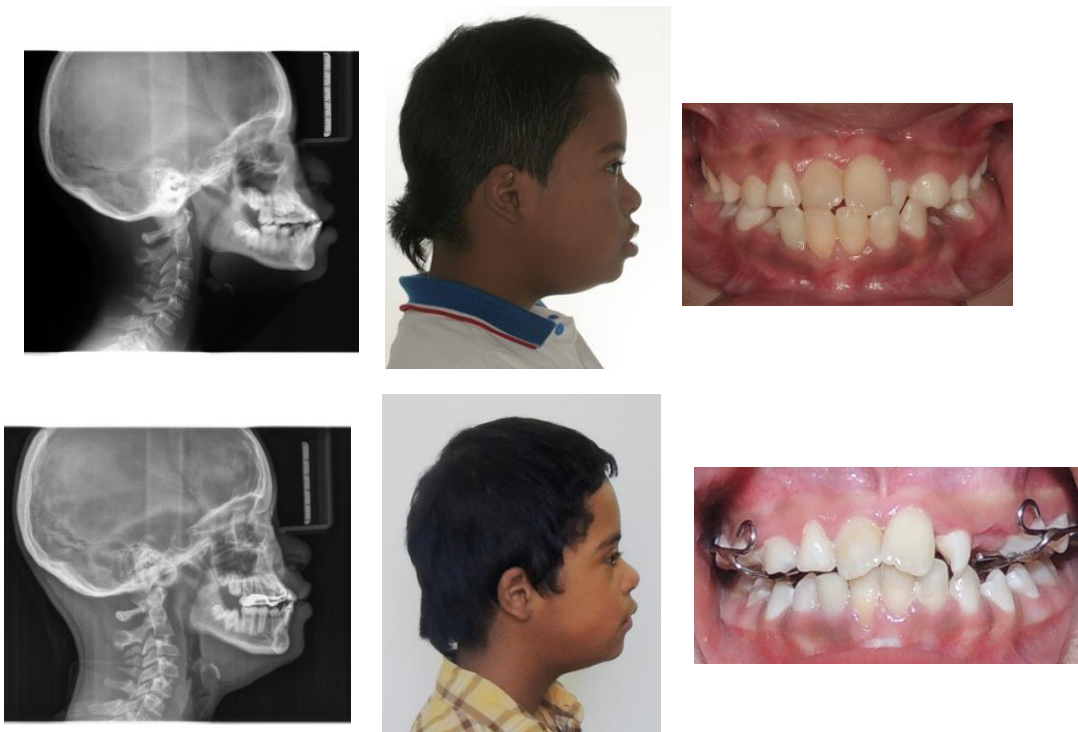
Cephalic X-ray, picture of facial profile and frontal occlusion of a boy with Down syndrome, before and after treatment.
